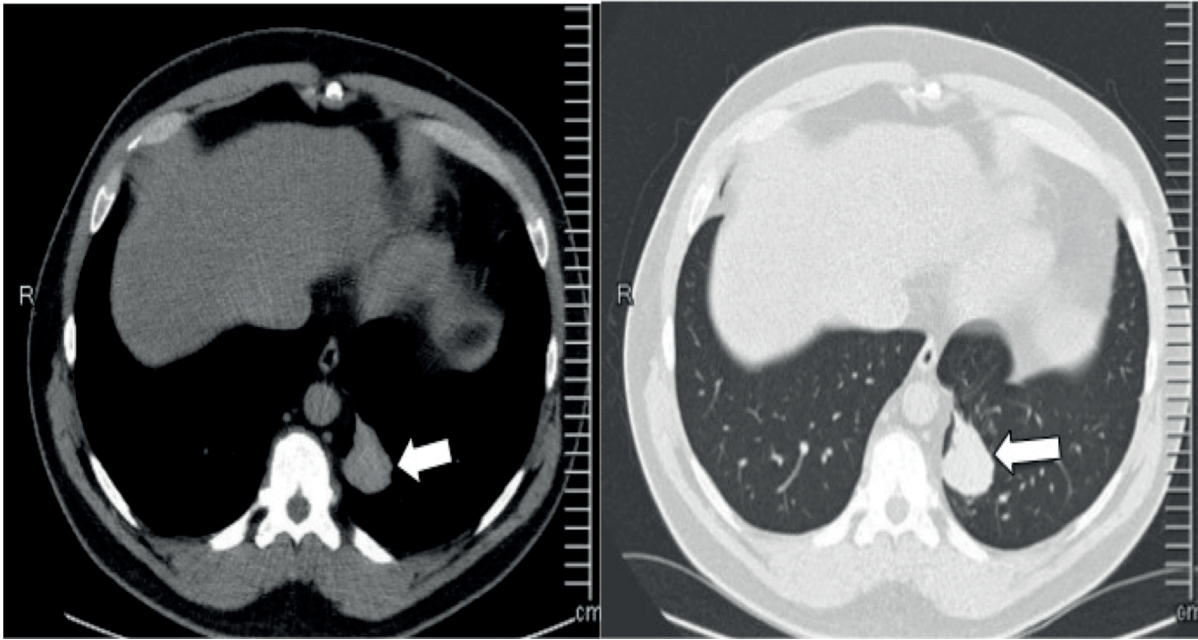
Thoracic computed tomography scan showing a paravertebral mass lesion in the left lower lobe (Arrows).
